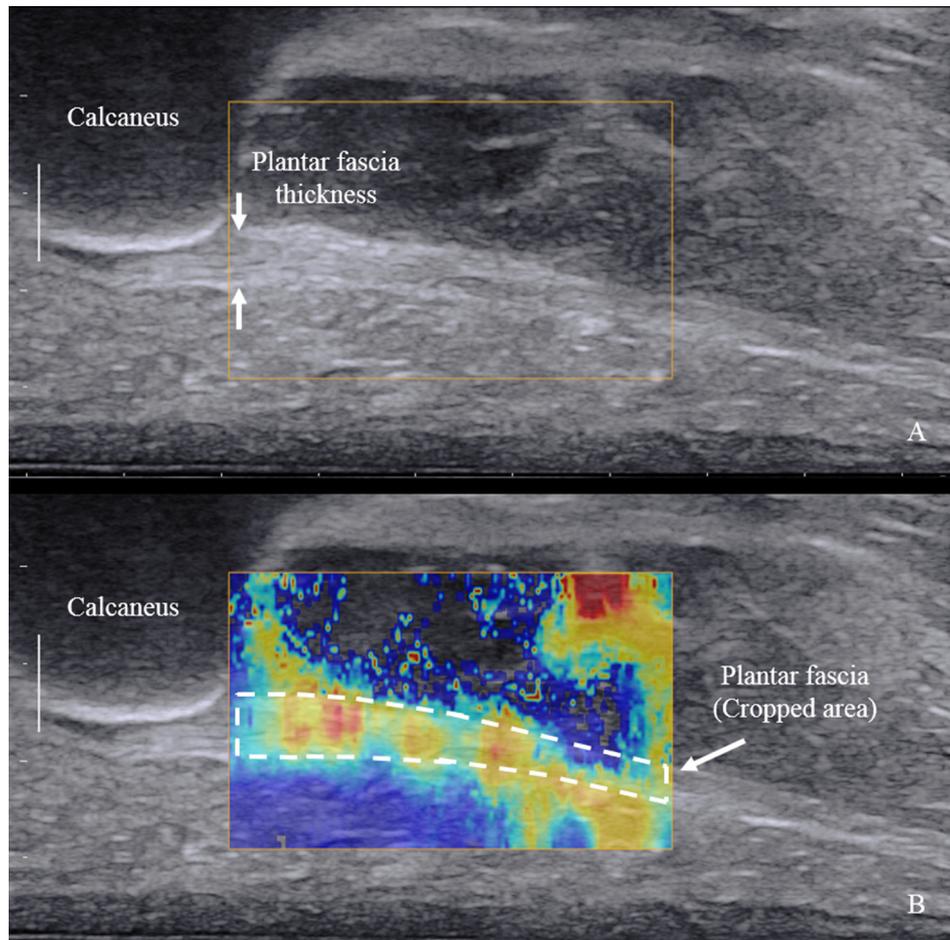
The ultrasound images of one representative participant. A: the longitudinal B-Mode image, B: the color-coded shear wave elastographic image superimposed on the B-Mode image. The fascia thickness and hypoechoogenicity were examined on the B-Mode image. The mean value of shear wave velocity was calculated from the manually cropped region (the dotted circle) on the shear wave elastographic image.
